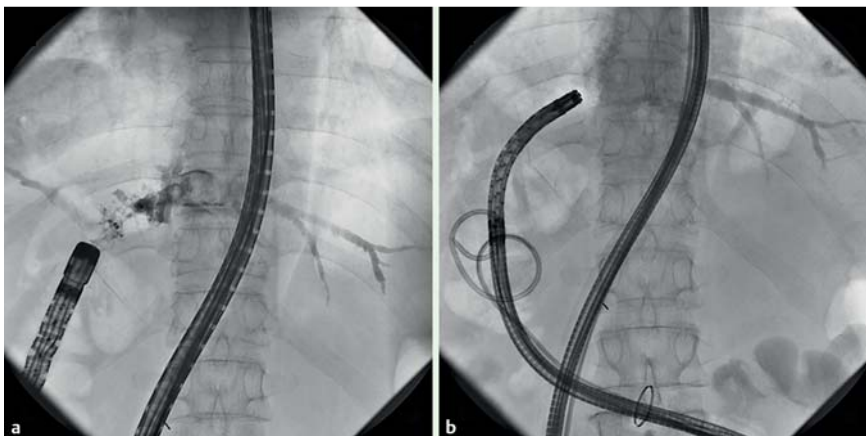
Radiographic images showing: a an attempt to extract the stones through the double-balloon enteroscope (DBE) from the distal side of the anastomosis; b an ultraslim endoscope, which had replaced the DBE, advanced into the bile duct.
